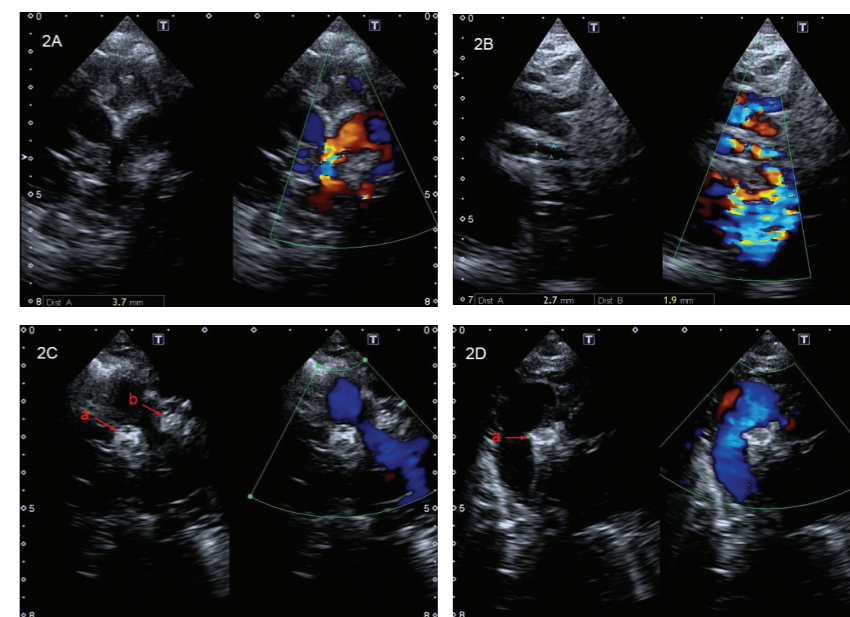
Echocardiogram showed a large PDA measuring 3.7mm from the descending aorta to the right pulmonary artery (A). A small PDA measured 1.7mm to the left pulmonary artery (B). Post occlusion showed no left pulmonary artery obstruction (C) and no descending aorta obstruction (D).
